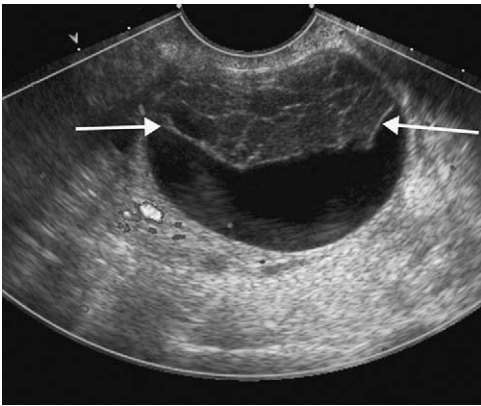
Hemorrhagic cyst with retracting clot. Transvaginal ultrasound shows an eccentric retracting clot (arrows) adherent to the cyst wall. Fibrin strands within the clot give it a “lacy” appearance.
